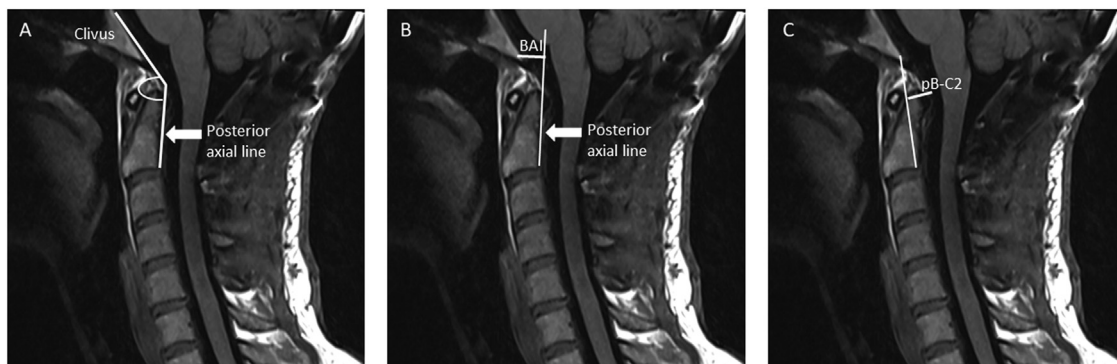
T1-weighted sagittal MRI of the craniocervical junction in a patient with EDS depicting A) clivo-axial angle, B) basion-axial interval, and C) the pB-C2 measurement.
